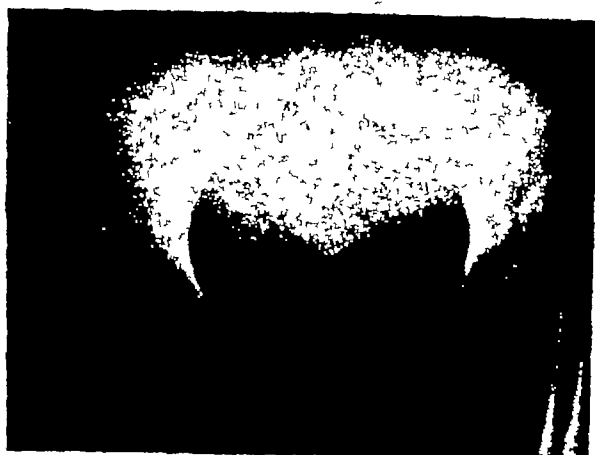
X-ray of patient shown in Fig 9A
